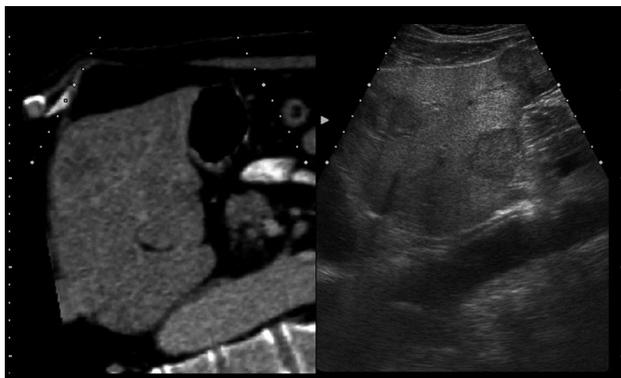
The left liver lobe ultrasound and computed tomography images are visualized at the same time in real-time virtual sonography.
